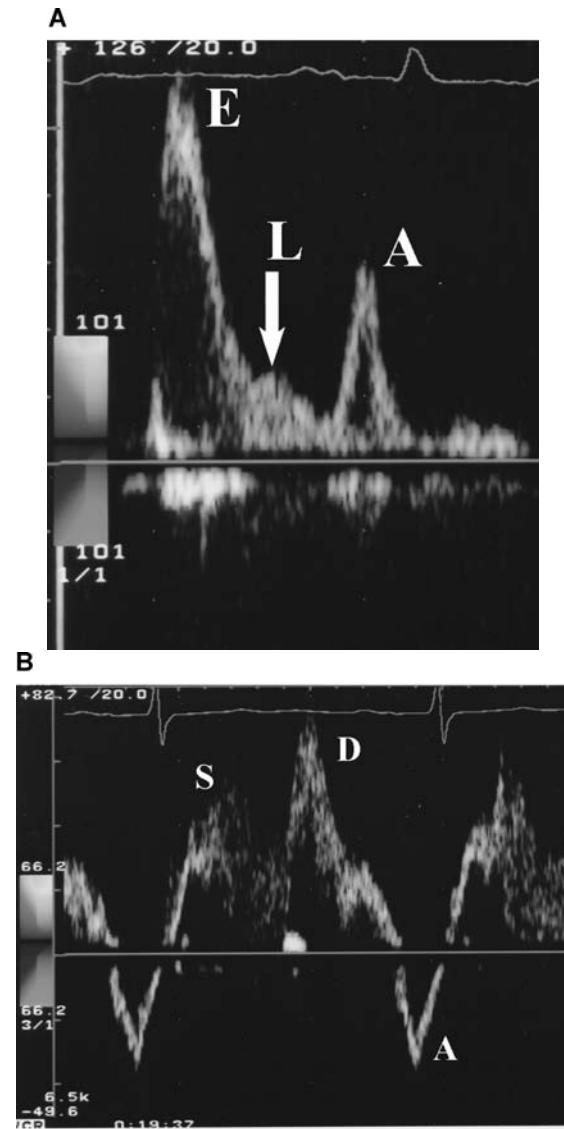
Mitral Doppler inflow in a patient with long-standing hypertension and moderate mitral regurgitation (with permission from: Kerut EK, McIlwain EF, Plotnick GD: *Handbook of Echo-Doppler Interpretation*, 2nd Ed. Elmsford, New York, Blackwell Publishing, Inc., 2004, p. 71.)
